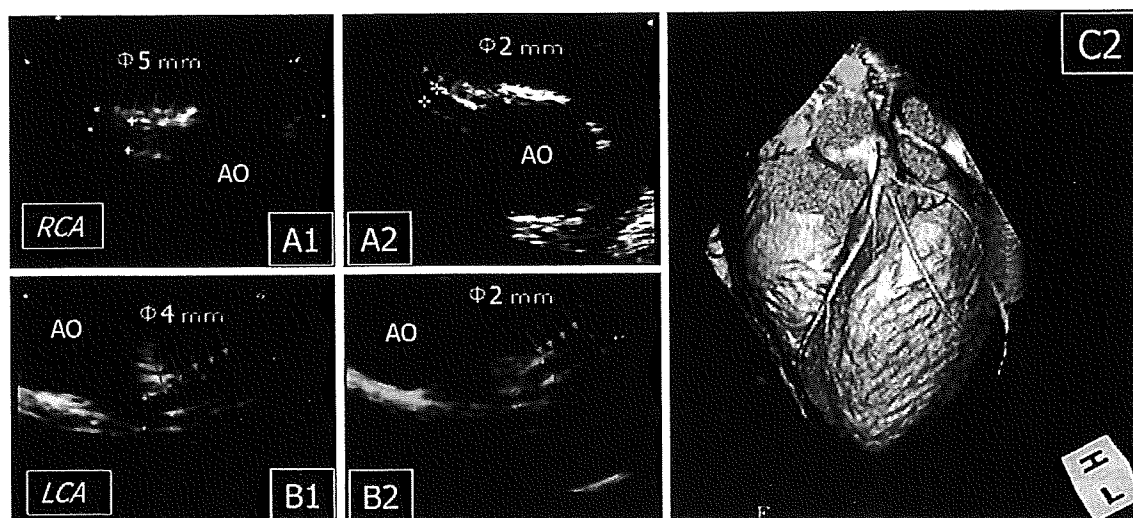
Echocardiography (A1, A2, B1, B2) and multislice spiral computed tomography (C2) of coronary arteries. The dilated right coronary artery (RCA) in patient 2 (A1) regressed after an unrelated-donor cord blood transplantation (A2: *arrows*). The dilated left coronary artery (LCA) in patient 5 (B1) resulted in a normal size after
